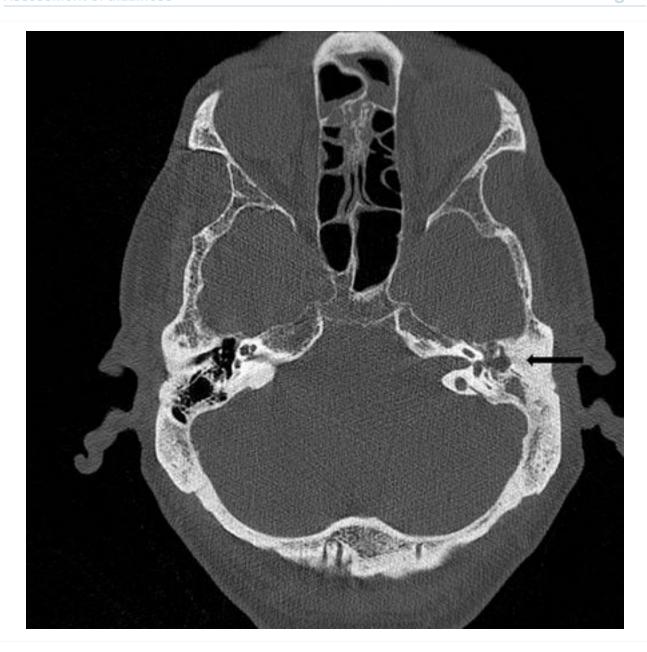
Cholesteatoma, axial CT scan
